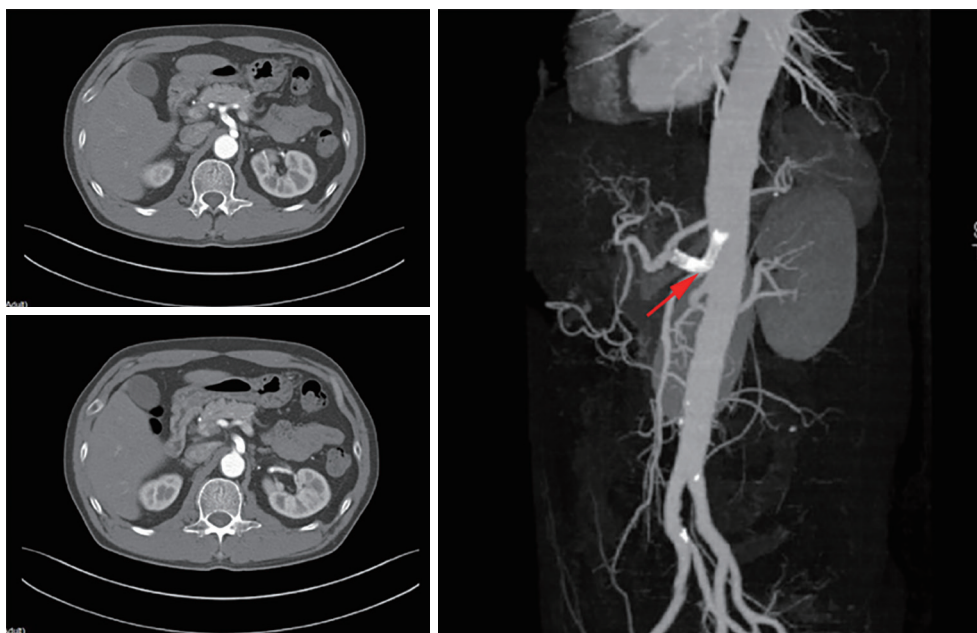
One year follow-up CTA of ACTD caused by MALS. CTA showed that after one-year follow-up, the stent was in good shape, the dissection and aneurysm was disappeared, and there was no blood flow limitation of the vessels. Arrow: celiac artery stent. CTA, computed tomography angiography; ACTD, aneurysmal celiac trunk dissection; MALS, median arcuate ligament syndrome.
